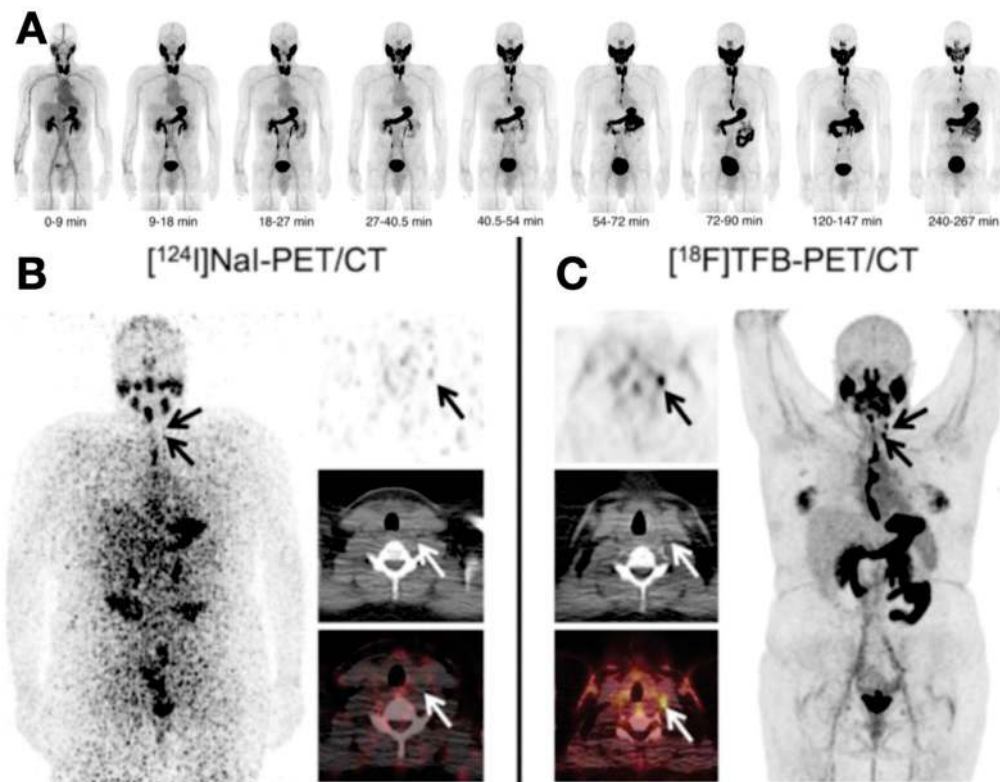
Evaluation of thyroid cancer via [^{18}F]TFB-PET/CT and [^{124}I]NaI-PET/CT. (A) Biodistribution of [^{18}F]TFB at various time points on PET images. [^{18}F]TFB accumulated rapidly in the thyroid and other normal tissues like the salivary gland and stomach within 10–30 min. Reproduced with permission from [50], copyright 2017 Society of Nuclear Medicine and Molecular Imaging. (B,C) A comparison between [^{124}I]NaI-PET/CT and [^{18}F]TFB-PET/CT in a 26-year-old patient post-thyroidectomy. (B) [^{124}I]NaI-PET/CT was unremarkable for PTC. (C) In contrast, [^{18}F]TFB-PET/CT revealed two foci in the left lateral cervical region. Reproduced with permission from [51], copyright 2018 Wolters Kluwer Health.
